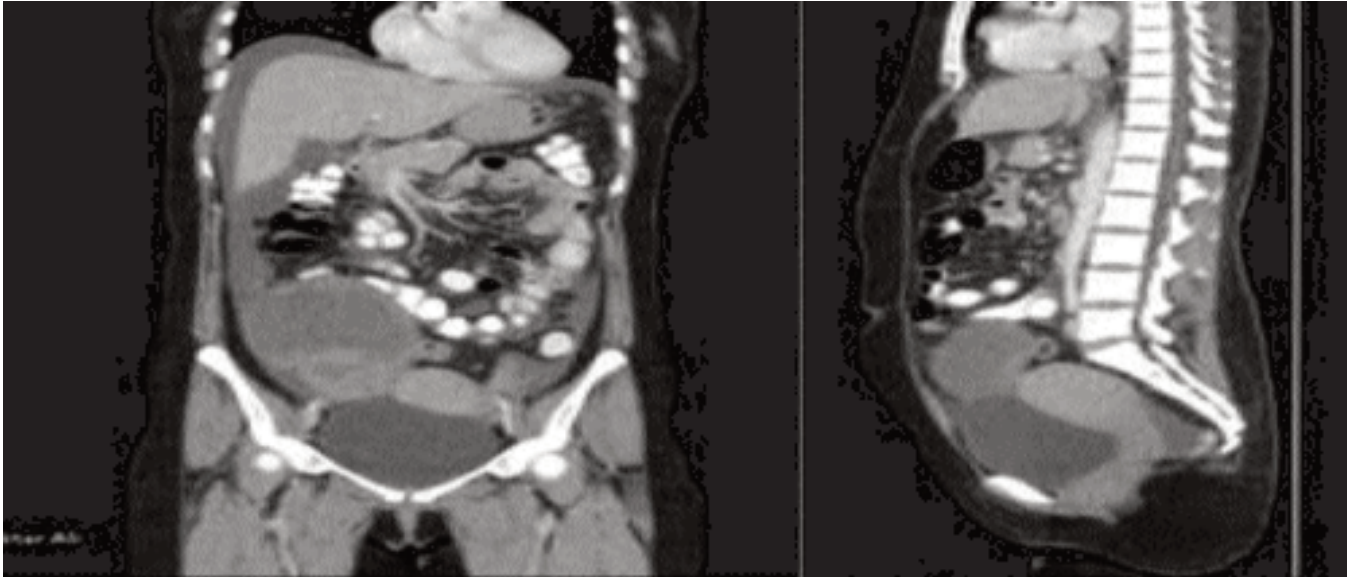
CT Scan images complex solid cum cystic right adnexal mass around 13x8.6x12.6cms.
